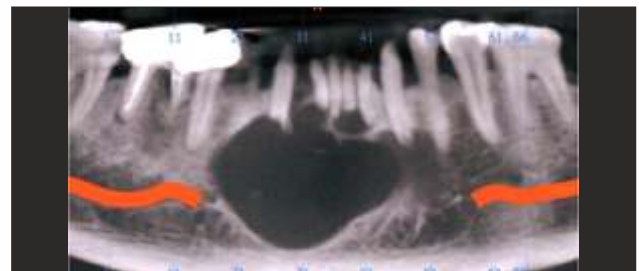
CBCT View showing well -defined hypo-density in relation with 44, 43, 42, 41, 31, 32, 33 and 34.
